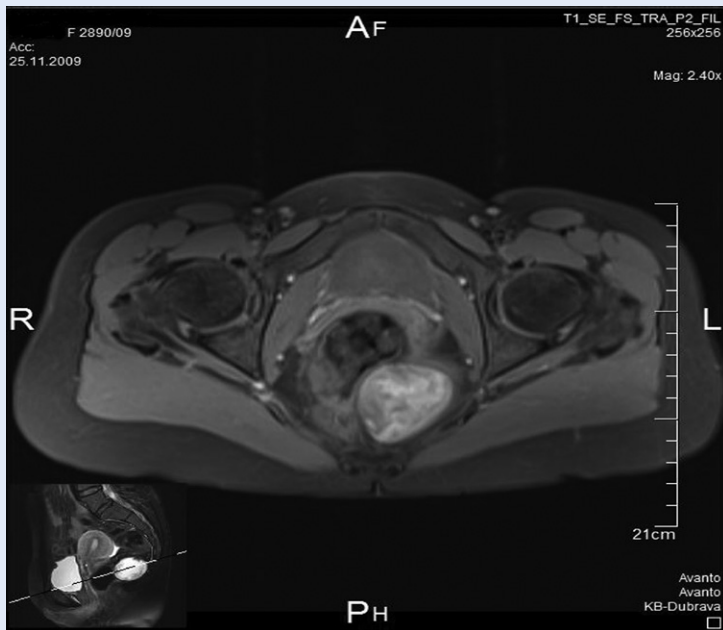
MRI T1 fat sat images: A sharply demarcated cystic lesion was found with heterogenous but mainly high signal intensity.
